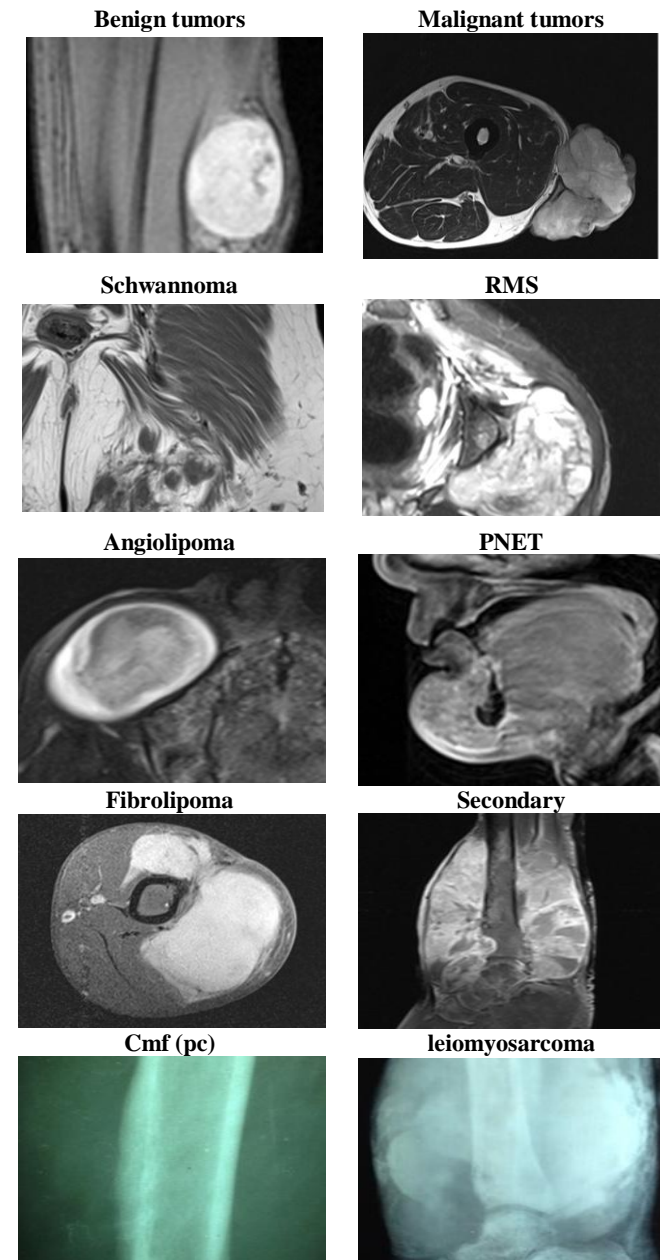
Representative examples of cases for two(Size ,depth) MRI parameters in benign and malignant tumours.
